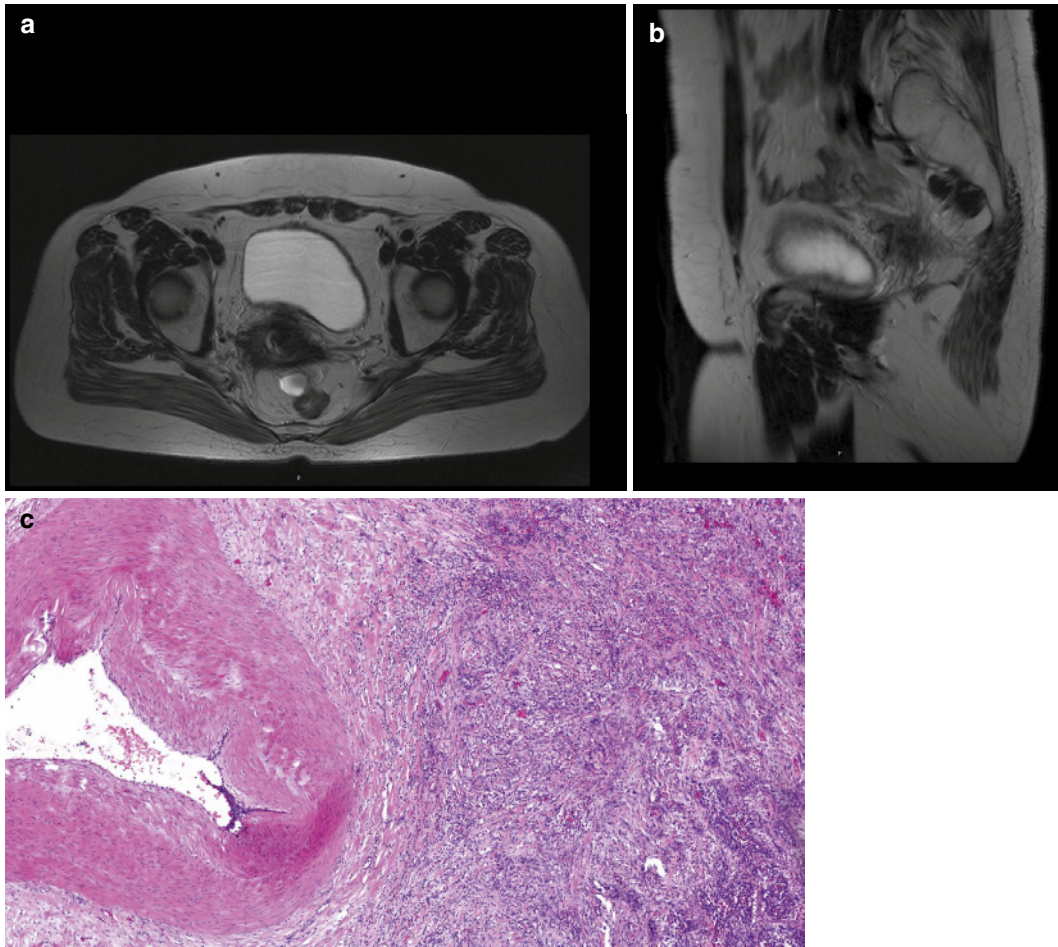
oT3b cervix carcinoma infiltrating the right vascular mesometrium up to the border of the parietal (somatic) subperitoneum fixing the uterus broadly at the right pelvic sidewall. T2-weighted transverse (a) and sagittal (b) MRI scans demonstrate tumor formations
